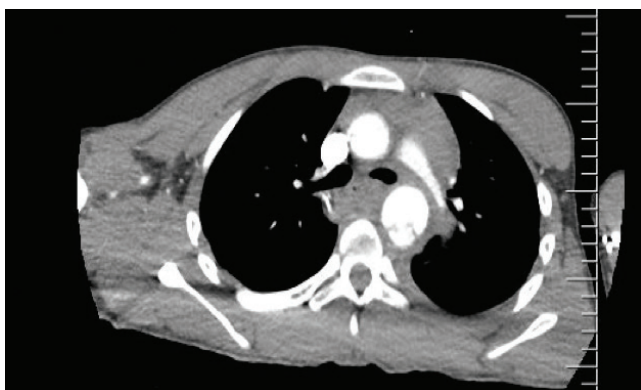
Thoracic CT showed hematoma around the aorta and transection line; the axial sections of thoracic computerised tomography showed hematoma around the aorta and transection line.
